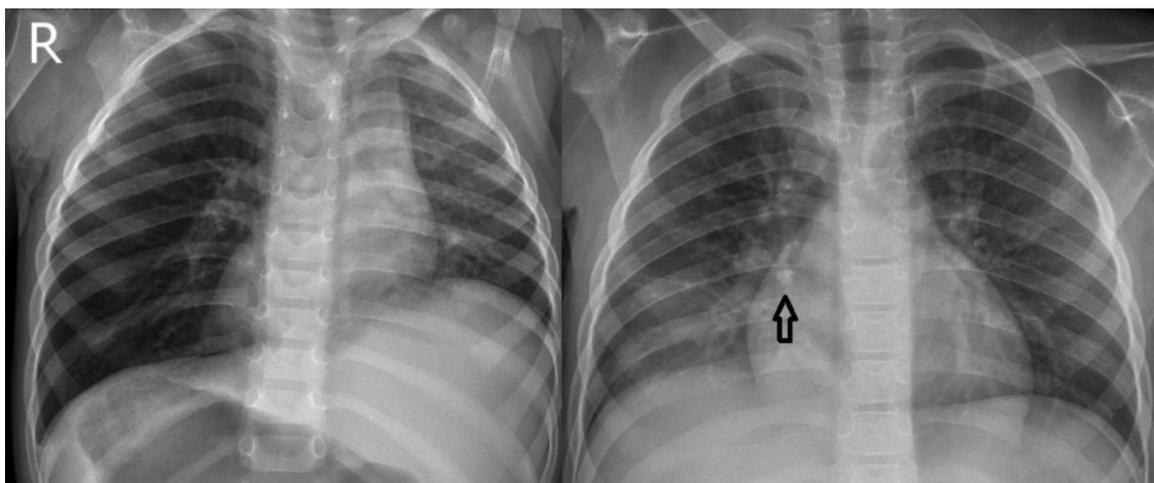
Chest X-ray of foreign body aspiration
